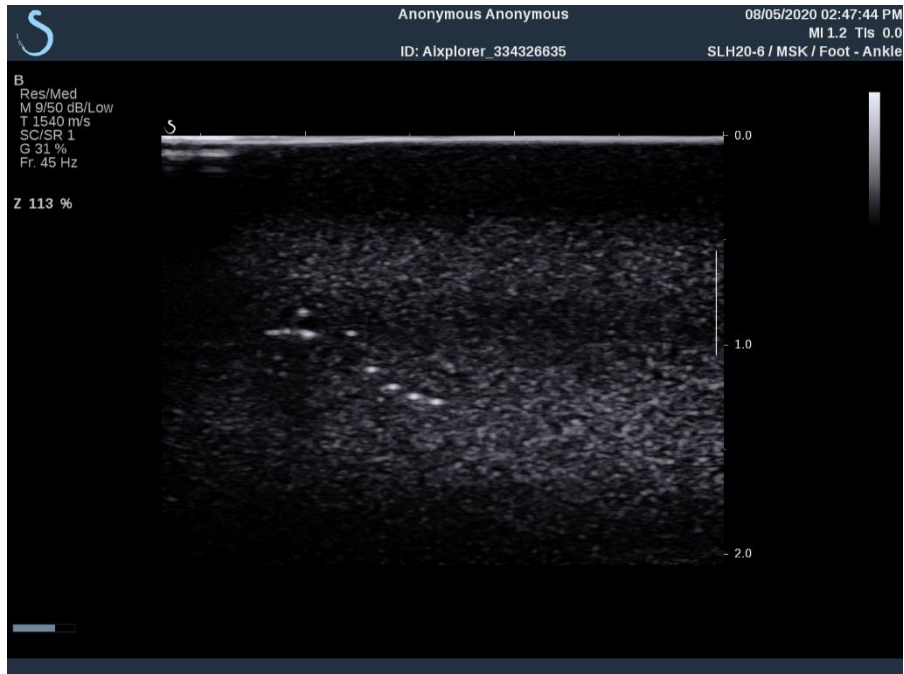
Ultrasound image used for the lateral/axial resolution check. Captured with the stock SLH20-6 probe.
